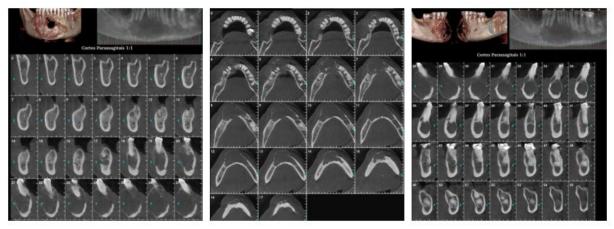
Computed tomography Source: author
